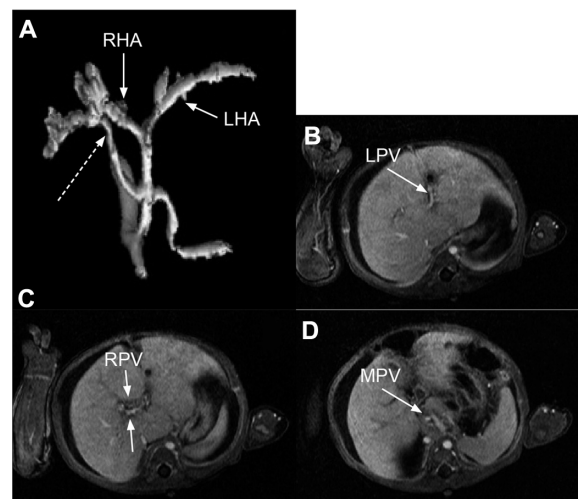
Seven-month-old female previously operated on for a hepatoportoenterostomy and enterointerostomy for biliary atresia returns with ascites and no flow in the main, left, and right portal veins on ultrasound (Case 23). She was treated with heparin for 5 days. A maximal intensity projection image from the arterial phase of axial VIBE images post-gadobutrol shows an accessory right hepatic artery originating from the celiac axis (dashed arrow, A). Contrast was also demonstrated in the patent main, right, and left portal veins, indicating partial recanalization (B–D). Nodular signal loss in the walls of these veins represents residual thrombus.
